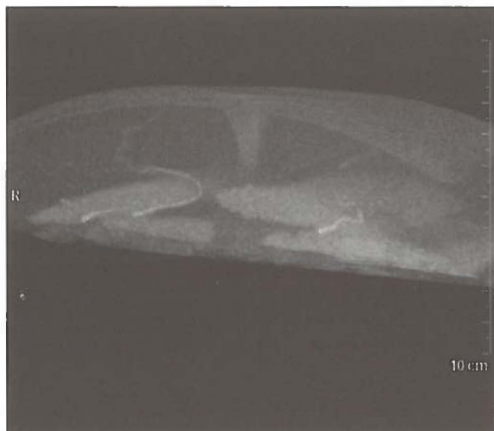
3D CTA image of a deep inferior epigastric perforator flap through which can be scrolled, which enables the user to view the vasculature from any direction. The direction of viewing is predominantly cranial as indicated by the green cube on the bottom left. The trunk of the umbilicus and the rectus abdominis muscles can be seen. On the left side of the umbilicus a perforator can be seen going medially around the rectus muscle and branching off towards the skin.
